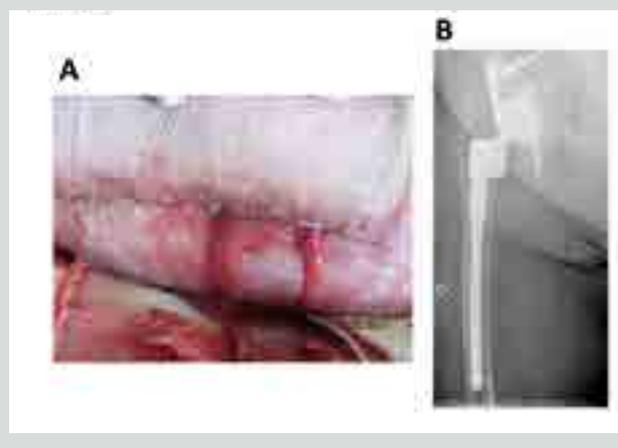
Eighty-year-old patient with purulent discharge (panel A) during a relapsing polymicrobial prosthetic-joint infection. The prosthesis was previously already change four times in the past for infections. As there was no prosthesis loosening at X-Ray, it was difficult to imagine an explantation without serious bone damage (fracture) and peroperative risk of complications (bleeding) or death
